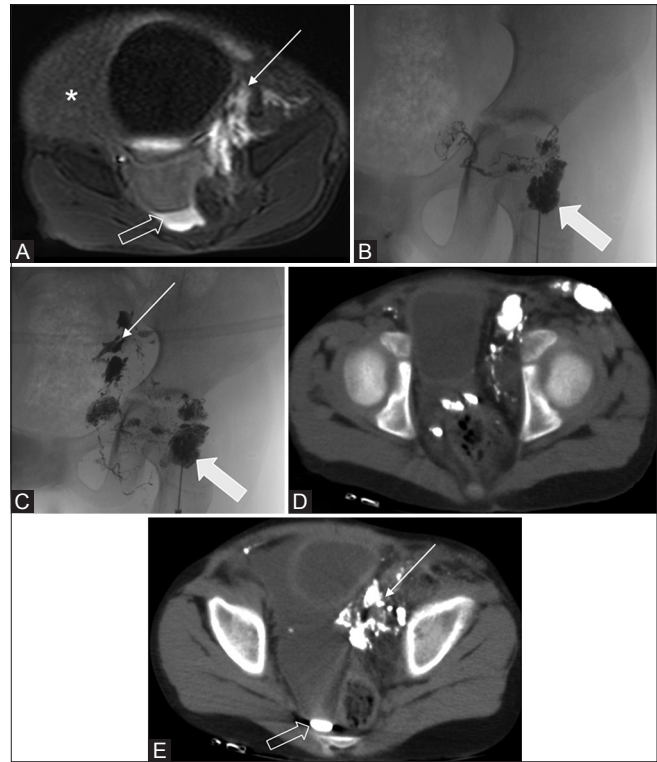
(A-E): Intranodal MR lymphangiography image (A) showing pooling of contrast (thin arrow) in the cystic spaces of residual lymphangioma in the left lateral pelvic wall and ascites (asterisk). There is layering of contrast in the dependent part of the rectovesical pouch (outlined arrow) suggesting contrast leak. Images (B and C) showing an intranodal injection of lipiodol (thick arrow) which is seen to opacify the lymph nodes, lymphatics, and the cystic spaces of lymphangioma. The post-procedure CT scan (D and E) showing the distribution of lipiodol as well as leakage into the rectovesical pouch (CT: Computed tomography, MR: Magnetic resonance)
